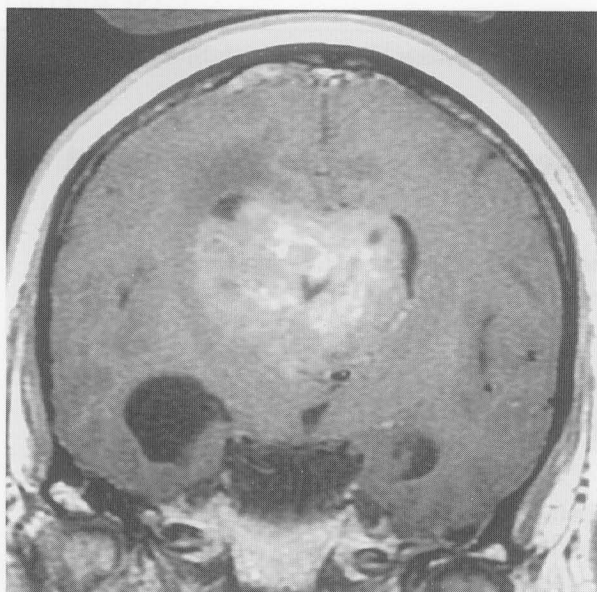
T1-weighted gadolinium-enhanced MR image before surgery showing a large tumor with a microcystic component and heterogeneous enhancement in the right lateral ventricle.
